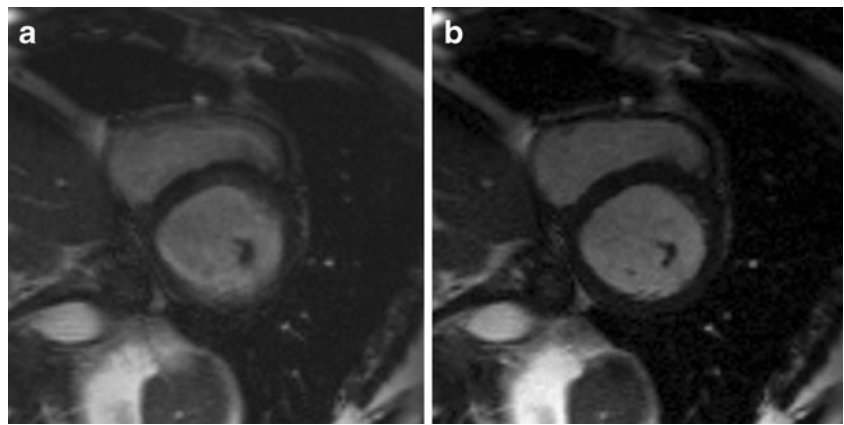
Mid-ventricular short-axis cine SSFP MR images of a 60-year-old male patient with suspected coronary heart disease acquired twice with PCG gating: whereas the initial acquired image (a) shows gating artefacts particularly at the lateral wall of the left ventricle, the repeated image (b) shows a good image quality without gating artefacts
